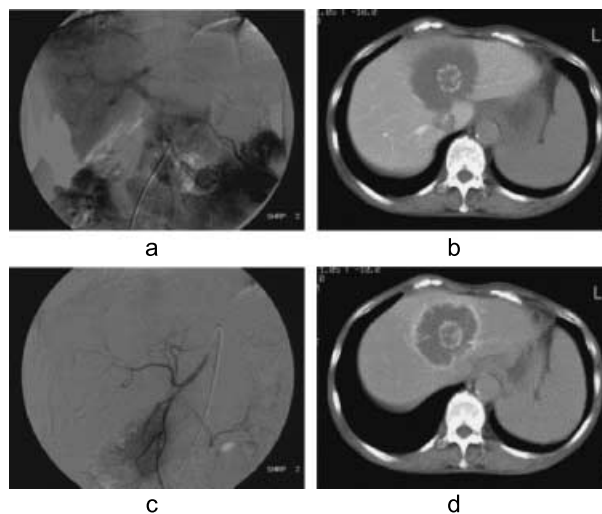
Angiography and CT during angiography (a) : Portography (b) : CT during the portography (CT-AP)(c) : Hepatic arteriography (d) : CT during hepatic arteriography (CT-A) Findings of the intratumoral enhancement and the vascular encasement were not detected in all these studies. Only the region around the lobular-shaped nodule was enhanced on CT-A.
